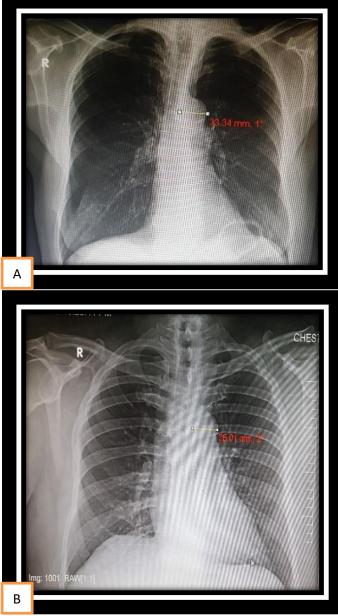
Aortic knob width (AKW) measurement method in chest radiography. A, AKW in normotensive patient and B, AKW in hypertensive patient.
